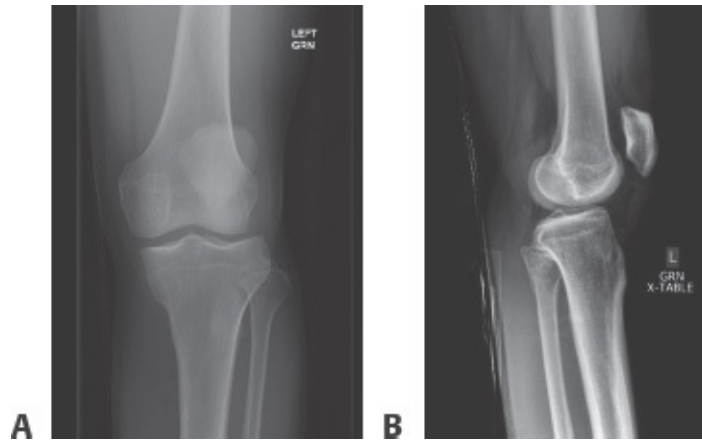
• A,B. Anteroposterior and lateral radiographs of a 32-year-old man with a sudden popping sensation and left knee pain after landing from a jump while playing basketball. Radiographs show a knee effusion, absence of fracture and patella alta best seen on the lateral projection.
